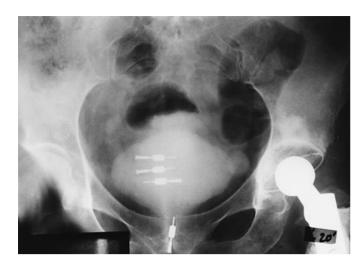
A palin abdominal X-ray film with three In-FlowTM inserts that have migrated into the bladder. Note also another device in its correct location inside the urethra.
